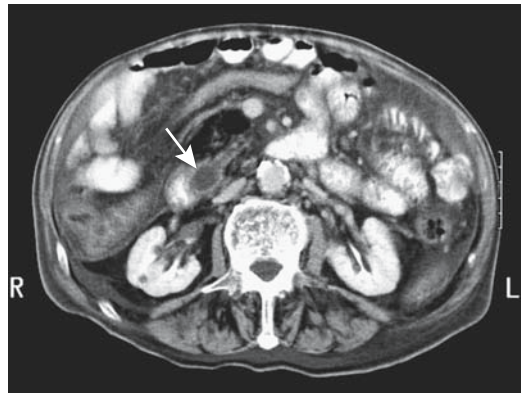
Choledochocoele in an 85-year-old man. Contrast-enhanced computed tomography (CT) reveals a dilated distal common bile duct indenting the descending duodenum (arrow). More superior images identified a dilated gallbladder. Surprisingly, the patient was not jaundiced. (Courtesy of Patrick Fultz, M.D., University of Rochester.)
